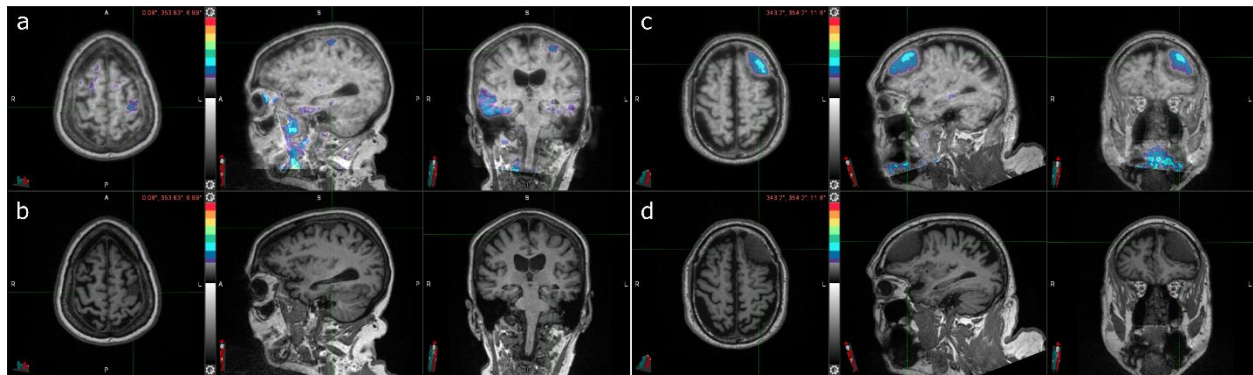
Two cases of incidental meningioma with tau PET uptake. (a) Tau PET coregistered with MRI of a female participant in her 70s with a left frontal posterior meningioma (indicated by the crosshair) with tau radiotracer uptake. (b) Corresponding MRI image. (c) Tau PET coregistered with MRI of a male participant in his 70s with a left frontal meningioma (indicated by the crosshair) with tau radiotracer uptake. (d) Corresponding MRI image.
